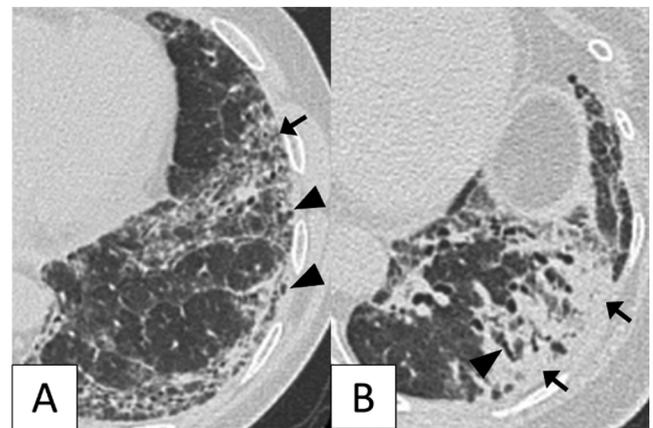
Typical CT images of interstitial lung disease-associated connective tissue disease. A, CT image at the level of the lung base in a 62-year-old woman with systemic sclerosis shows reticular opacity (arrow) and traction bronchiectasis (arrowheads). B, CT image at the level of the lung base in a 64-year-old woman with dermatomyositis shows consolidation (arrows) and traction bronchiectasis (arrowheads).
